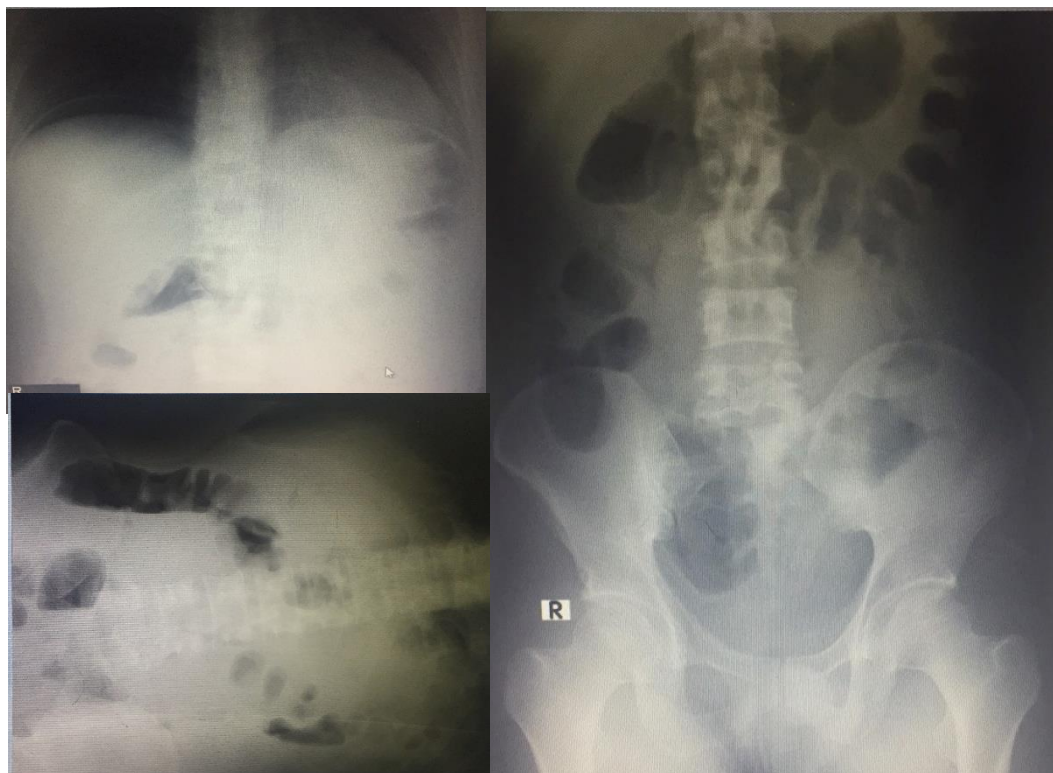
Radiographic 3 Way Abdominal X-RAY
